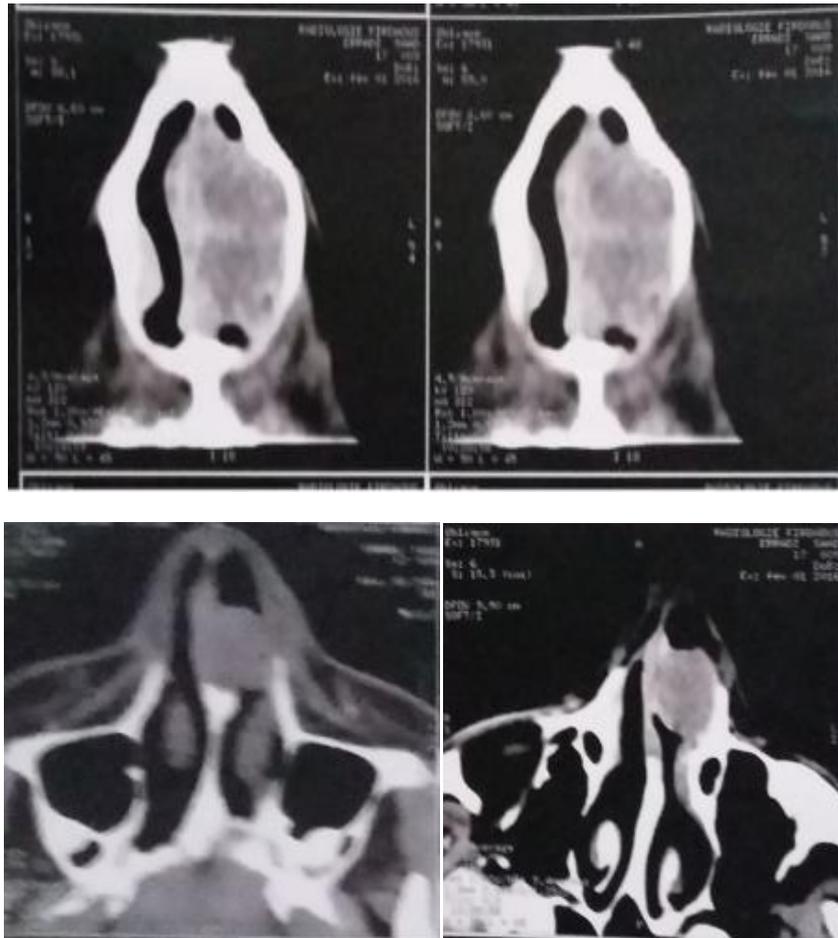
Nasosinusal bone imaging. Axial and coronal CT slices with and without contrast medium: tissular left nasosinusal aspect
